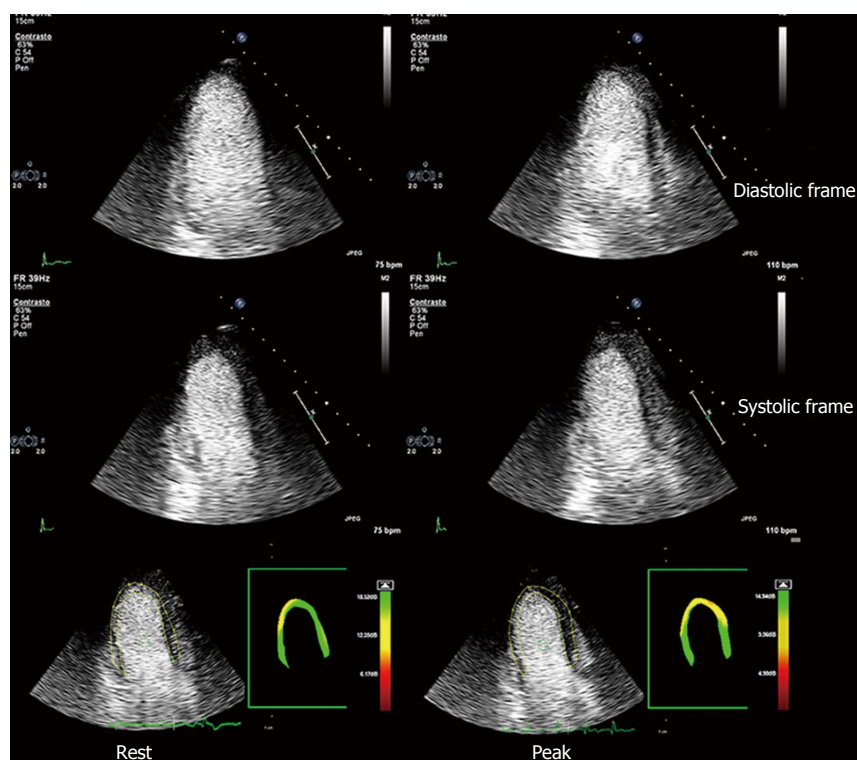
Myocardial contrast stress echocardiography. Apical three-chamber view of a patient with previous by-pass graft (left internal mammary artery graft onto left anterior descending coronary artery). Baseline diastolic and systolic frames on the left, top and intermediate rows, respectively; peak stress diastolic and systolic frames on the right, top and intermediate rows, respectively. Baseline and peak stress myocardial perfusion parametric quantification are displayed, respectively, in the bottom left and right panels. At baseline, akinesis of the infero-apical region is evident, which is concordant with a transmural defect of perfusion of the same region. At peak stress, no new wall motion abnormalities are detected, whereas parametric quantification of myocardial perfusion shows a large transmural defect of perfusion of all the apical regions and a subendocardial defect of perfusion of middle and basal anterior septum. A critical stenosis of distal mammary graft anastomosis was found on coronary angiography.
